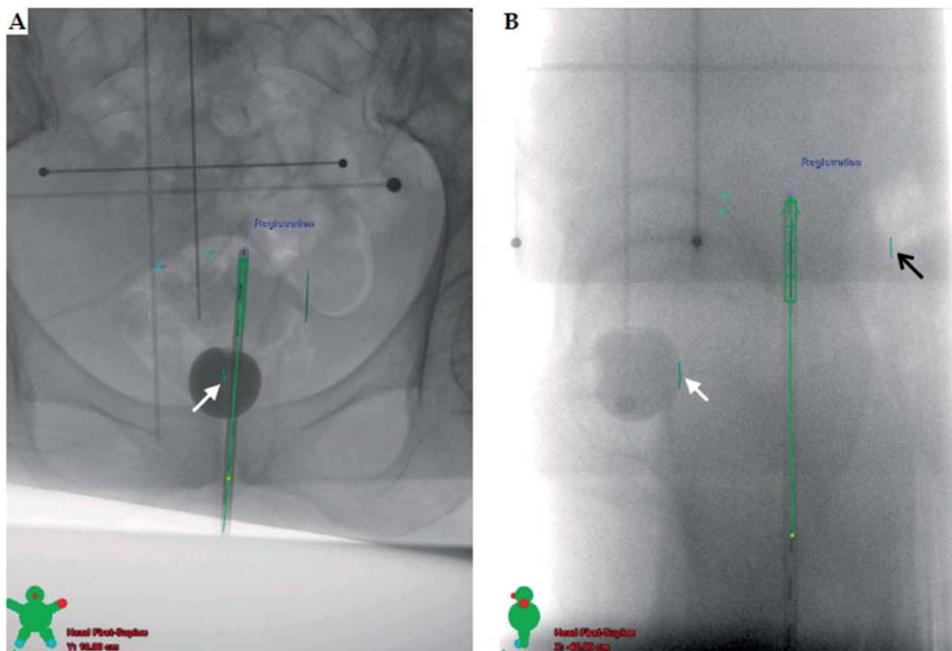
Example of simple orthogonal X-ray images used for localization of vaginal cylinder and ICRU bladder (white arrow) and ICRU rectal reference points (black arrow) per the ICRU 38 report. A) Anteroposterior projection. B) Lateral projection
